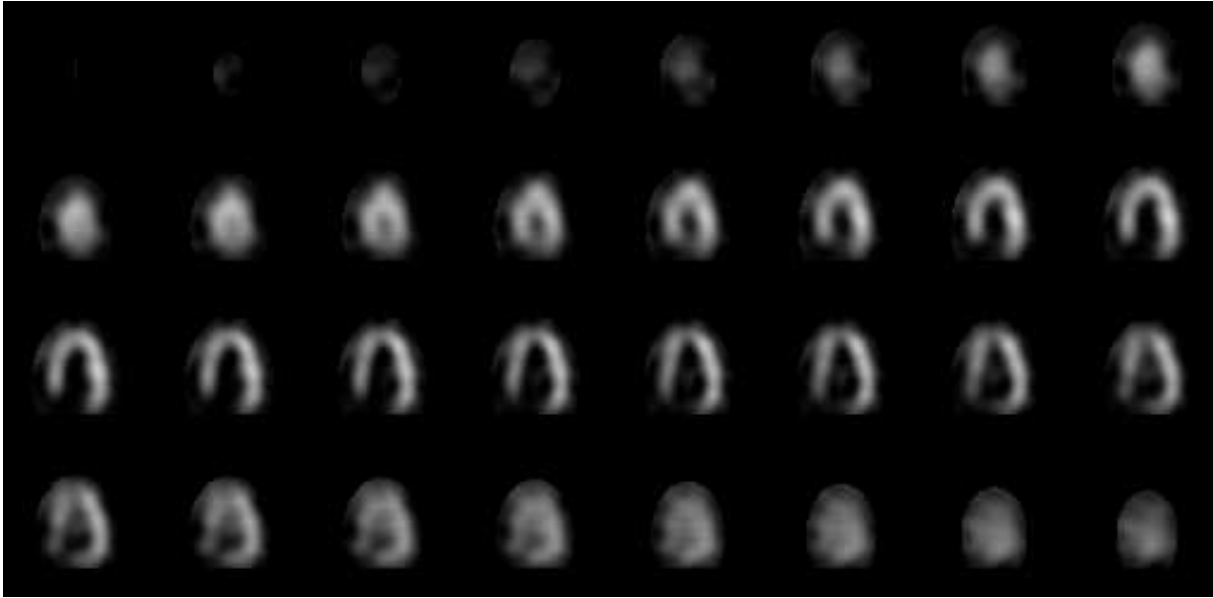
3D image of the left ventricle - SPECT image (the order of sections reads from left to right and from top to bottom and descends through the heart).
